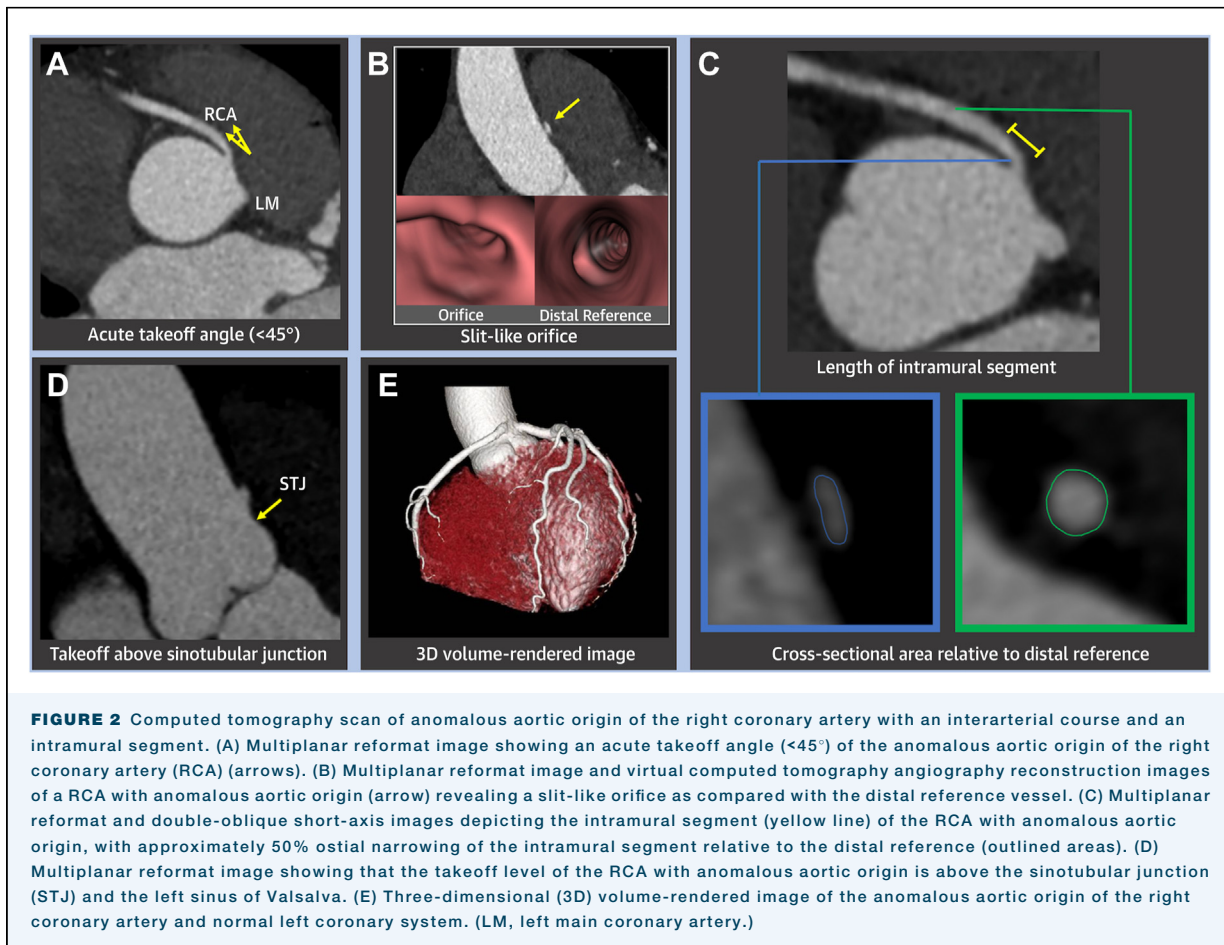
Computed tomography scan of anomalous aortic origin of the right coronary artery with an interarterial course and an intramural segment. (A) Multiplanar reformat image showing an acute takeoff angle ($<45^\circ$) of the anomalous aortic origin of the right coronary artery (RCA) (arrows). (B) Multiplanar reformat image and virtual computed tomography angiography reconstruction images of a RCA with anomalous aortic origin (arrow) revealing a slit-like orifice as compared with the distal reference vessel. (C) Multiplanar reformat and double-oblique short-axis images depicting the intramural segment (yellow line) of the RCA with anomalous aortic origin, with approximately 50% ostial narrowing of the intramural segment relative to the distal reference (outlined areas). (D) Multiplanar reformat image showing that the takeoff level of the RCA with anomalous aortic origin is above the sinotubular junction (STJ) and the left sinus of Valsalva. (E) Three-dimensional (3D) volume-rendered image of the anomalous aortic origin of the right coronary artery and normal left coronary system. (LM, left main coronary artery.)
